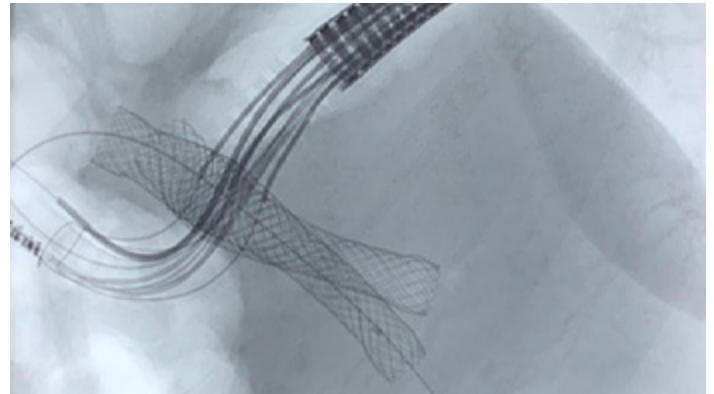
Examples of X-ray visualization by the radiolucent tip of aScope™ Duodeno
